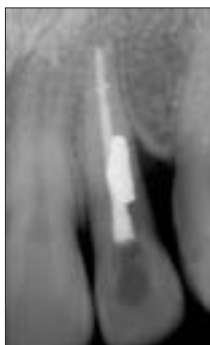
Follow-up radiograph at four years; the apical periodontitis has healed, and the crestal bone margin has stabilized. Although the prognosis remains questionable, the tooth being functional achieves the goals of therapy as set by the patient.
